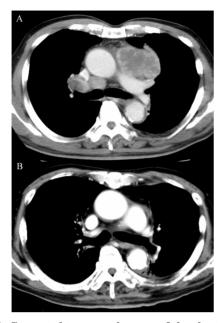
Computed tomography scan of the chest in case 9 showed a bulky mass in the anterior mediastinum with mediastinal and right hailer lymphadenopathy in April 2006 (A); Complete remission was achieved by treatment with cisplatin and docetaxel accompanied by concurrent thoracic irradiation, and the patient was alive for over 6 years without disease progression at the time of reporting (B).
